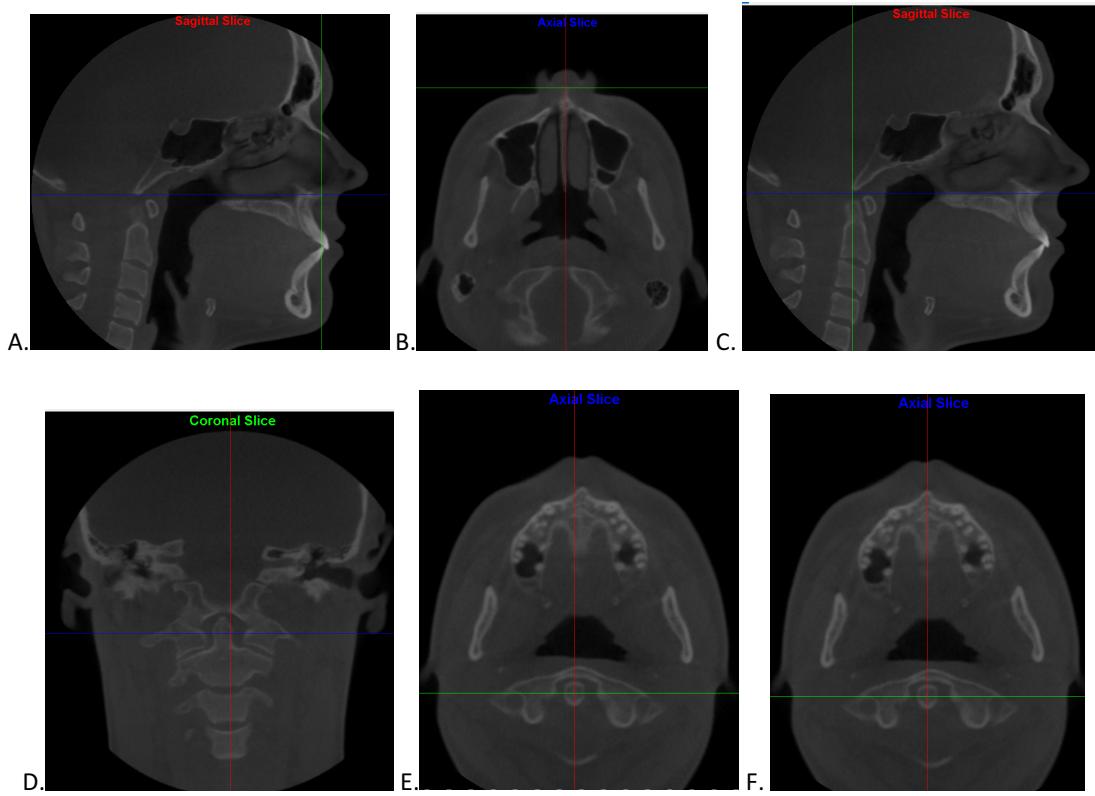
CWRU standardized CBCT image orientation procedure. A.) In the sagittal view, move the cross to ANS. B.) In the axial view, move the red vertical line to bisect ANS. C.) In the sagittal view, move the green vertical line to bisect the vertebrae. D.) In the coronal view, move the blue horizontal line down to bisect atlas. E.) In the axial view, move the red vertical line to bisect odontoid process. F.) Rotate the slice around odontoid process so the red line bisects ANS as well.
